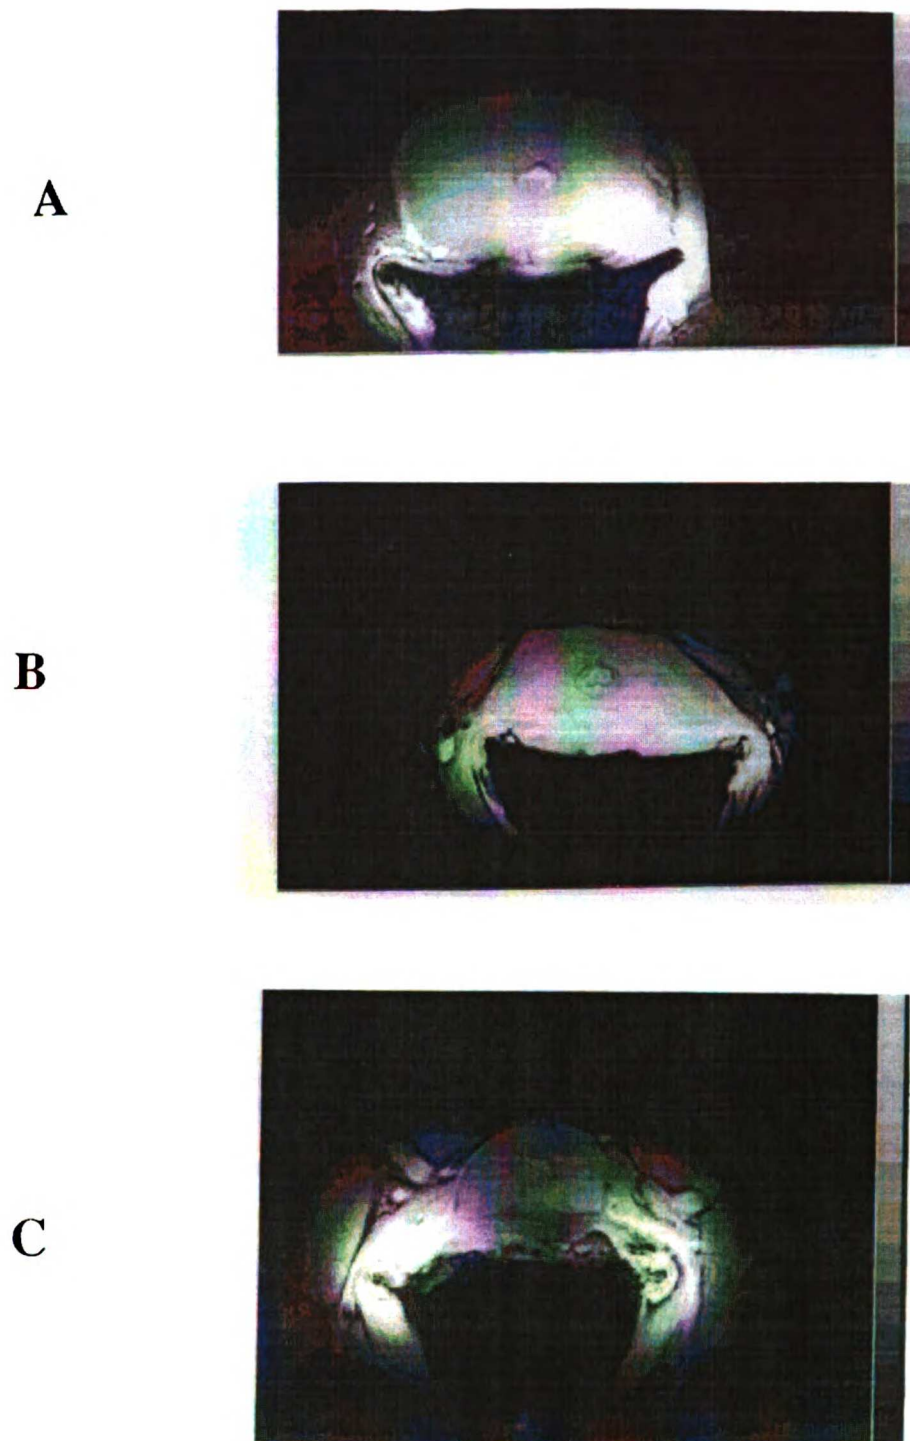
Serial transaxial gradient-refocussed MR images. (A) Prior to orchietomy; (B) 1 week after orchietomy; (C) 3 weeks after orchietomy. Image parameters are: TR = 100 msec, TE = 9 msec, FOV = 8.0 x 8.0 cm², 256 x 256 pixel matrix, slice thickness = 3mm, and 2 acquisitions per phase-encoding step.
